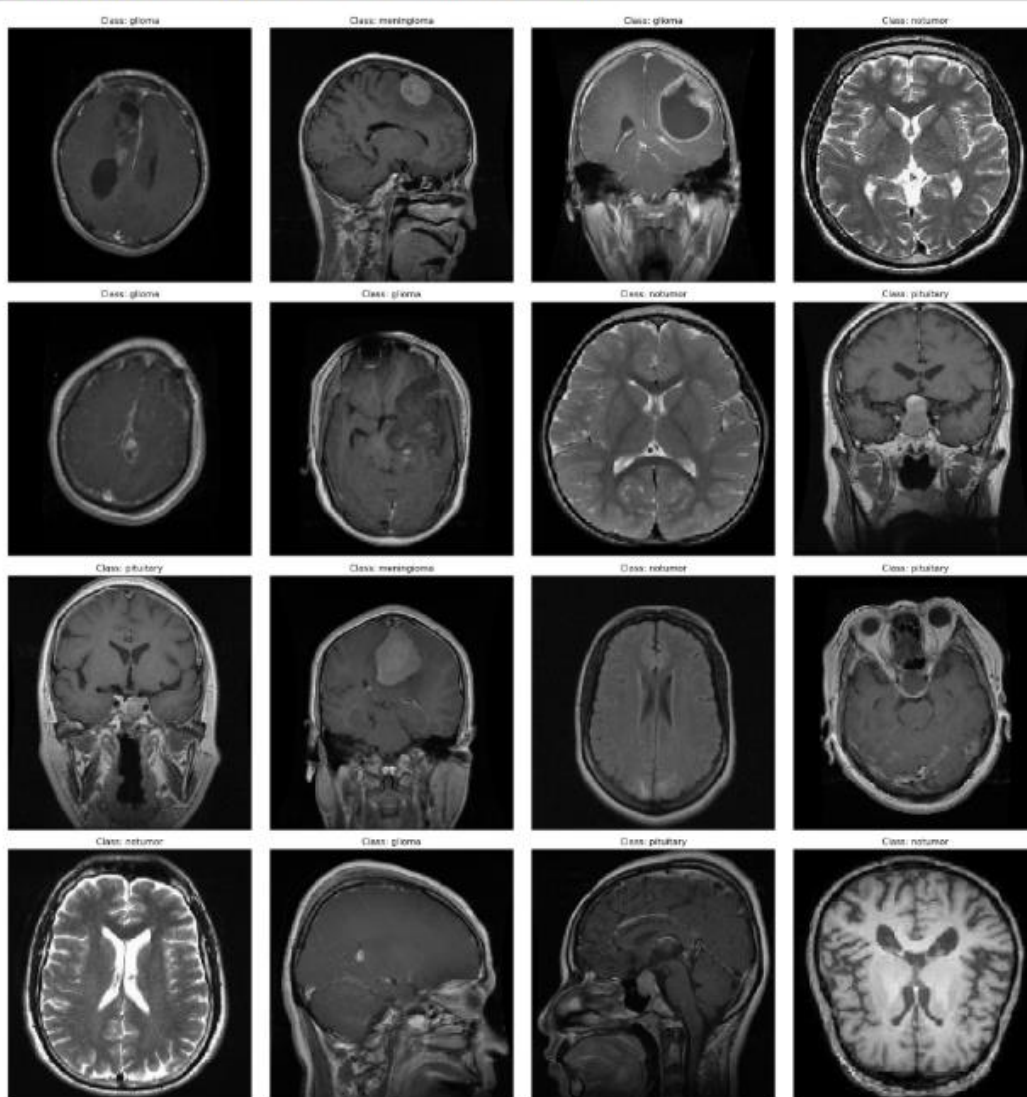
Data visualization of the MRI scans
